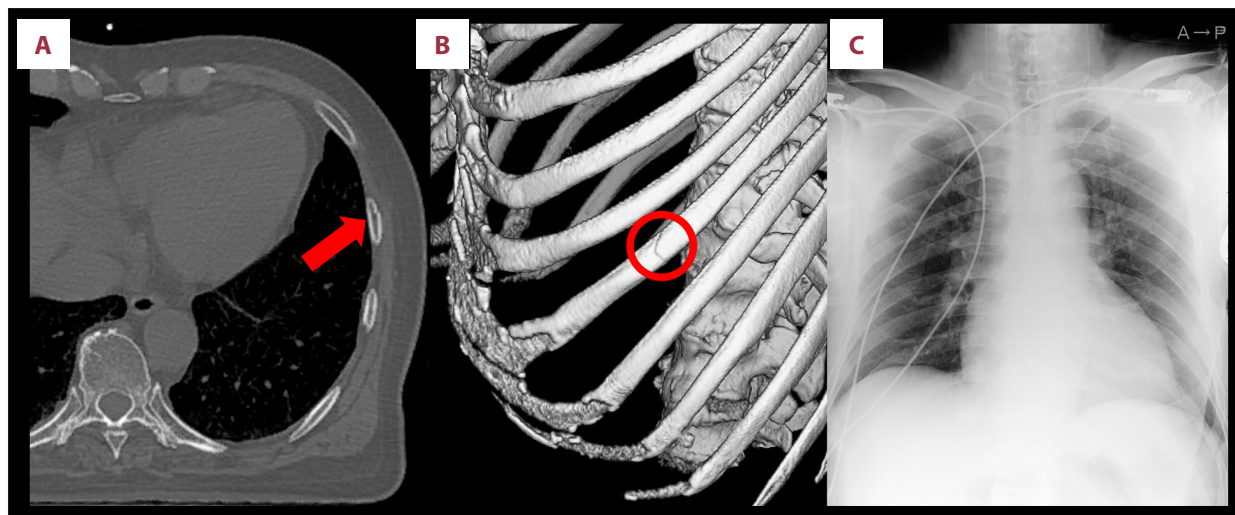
Chest X-ray and computed tomography findings in the emergency department. Computed tomography revealed the fracture of the left seventh rib (A, B), and chest X-ray revealed mild cardiomegaly without pleural effusion or pulmonary congestion (C). A red arrow and a circle indicate the fracture site.
